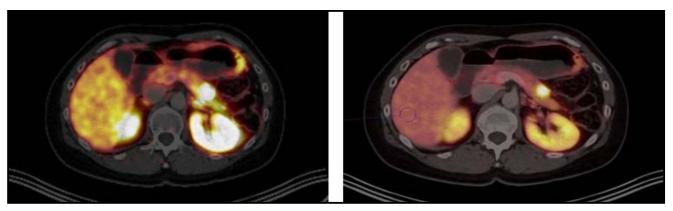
Hypermetabolic lesion in the body/tail of the pancreas measuring approximately 1.6 x 1.6 cm with a maximum SUV of 41.
